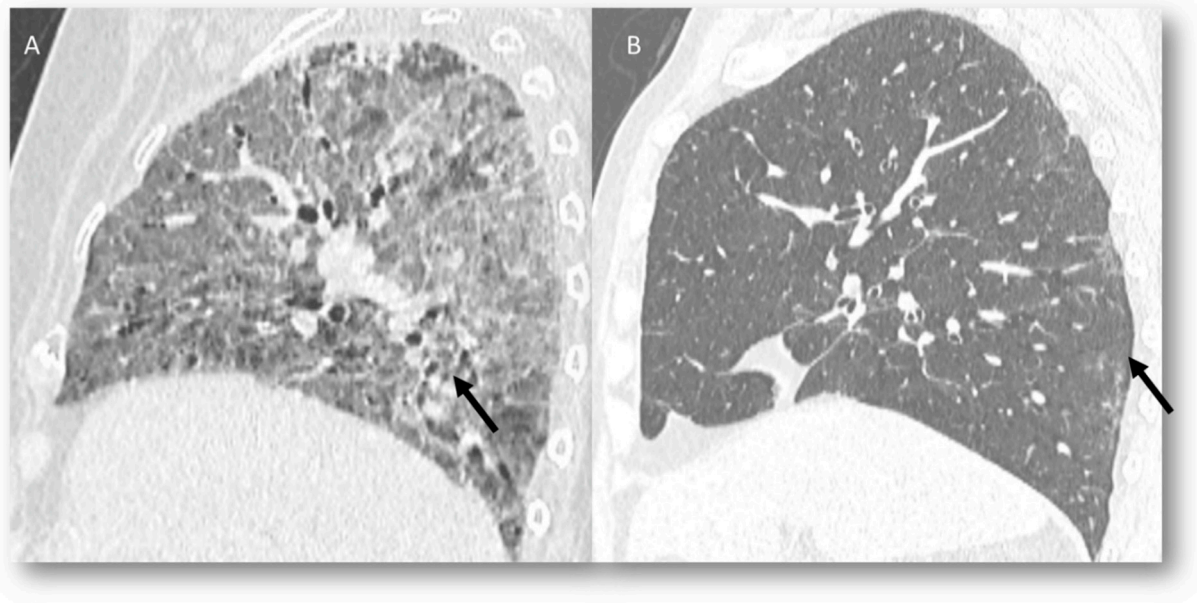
CT assessment ((A): sagittal plane) of CIP: acute interstitial pneumonia (AIP)–acute respiratory distress syndrome (ARDS) pattern (arrow). After steroids treatment ((B): sagittal plane); subpleural distribution bilaterally of ground-glass opacities (arrow).
